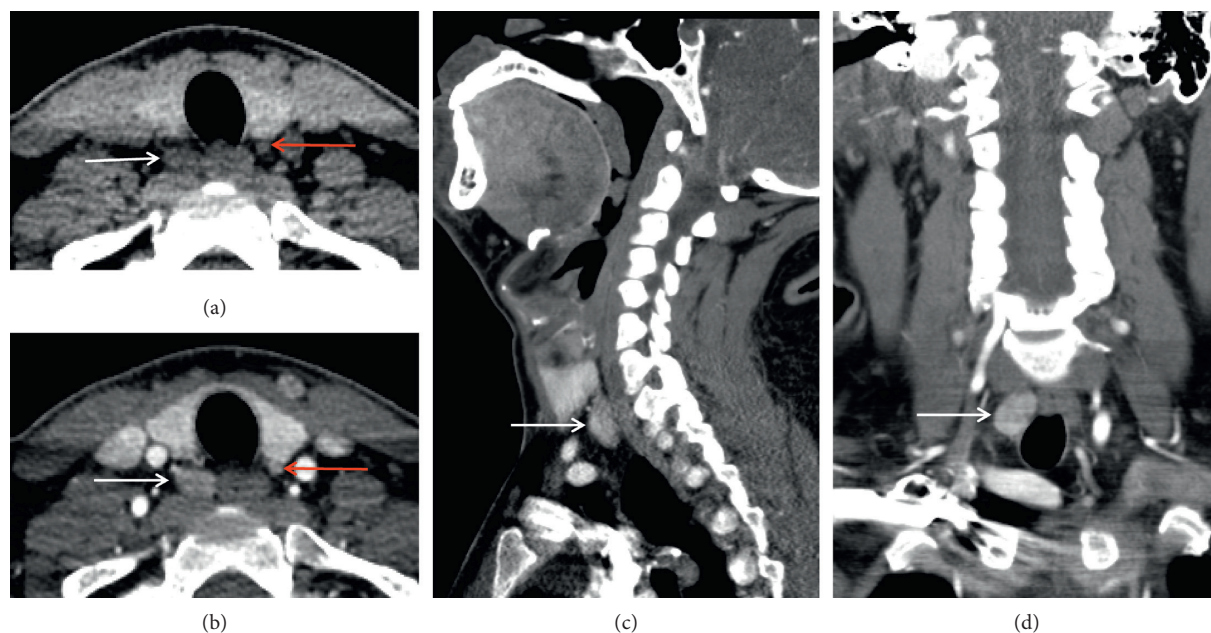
Multigland disease on four-dimensional computed tomography (4DCT). A 44-year-old female presents with recurrent hyperparathyroidism after prior right inferior parathyroidectomy. Axial precontrast (a) and postcontrast (b) early arterial phases show a moderately enhancing overly descended right superior parathyroid adenoma (white arrows) and a small hyperenhancing orthotopic left inferior parathyroid adenoma (red arrows). Coronal (c) and sagittal (d) views similarly demonstrate the overly descended right superior parathyroid adenoma (white arrows).
